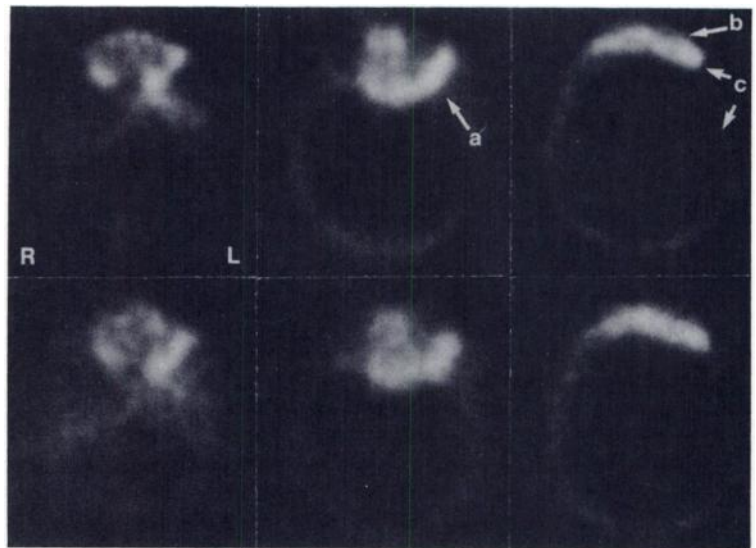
SPECT of 48-yr-old female operated on for meningioma of left sphenoid ridge. Osteogenic reactions in left sphenoid wing (a) and frontal bone (b), caused by tumor recurrence or inflammatory process, and postoperative defect (c) are more precisely delineated in sections of upper row (radius of rotation = 14 cm) than in lower row (radius of rotation = 18.5 cm). Difference in radius was only 4.5 cm in this case but difference in image quality is quite clear.
